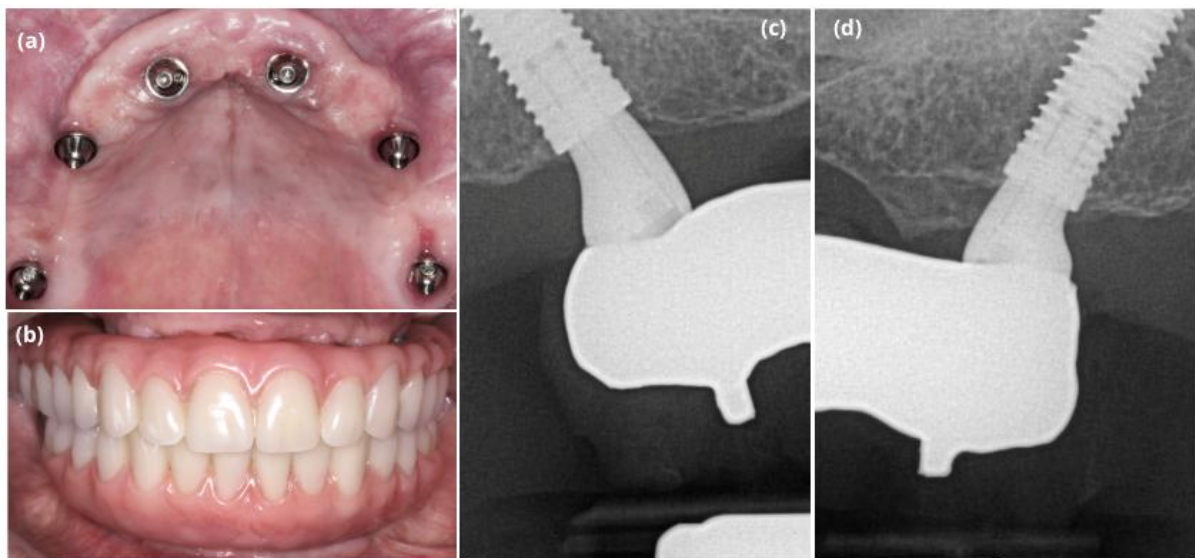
Twelve-month follow-up. Clinical occlusal view (a). Buccal view of the final prostheses (b). Periapical radiographs of the #17 and #27 regions (c-d).
